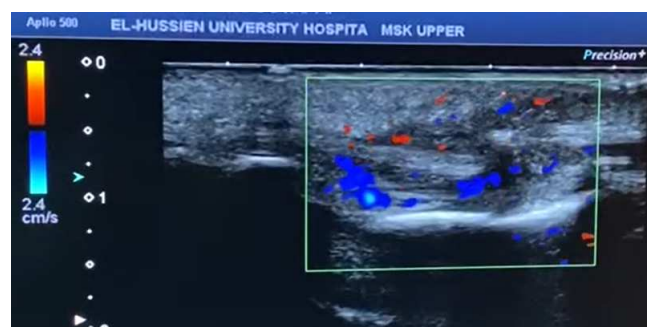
Colour Doppler ultrasound at suture site to assess the degree of tendon vascularity.
